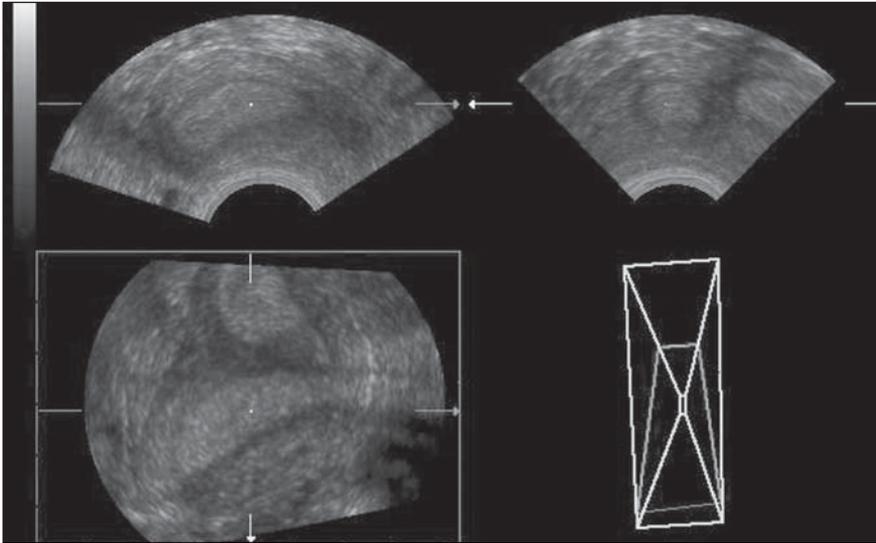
Double cavity uterus. Final diagnosis: bicornuate uterus. Transvaginal 3D multiplanar ultrasound. Observe asymmetrical endometrial cavities.
